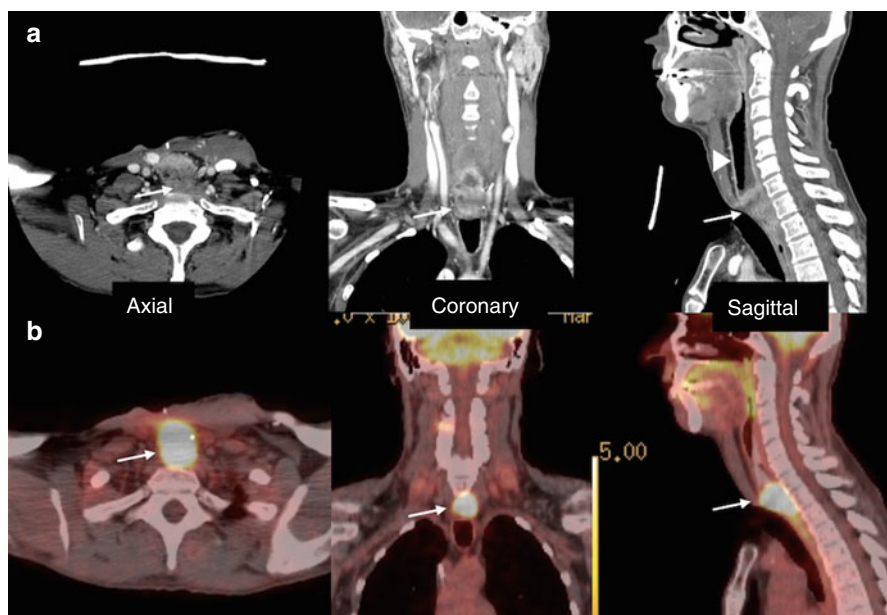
Primary staging for cervical esophageal cancer: (a) IV contrast-enhanced CT showing bulky tumor in the cervical esophagus (*arrow*) with compression of posterior trachea and pre-stenotic dilation of cervical esophagus (*triangle*). (b) Corresponding fused PET/CT showing SUV uptake in bulky tumor (*arrow*) of cervical esophagus
